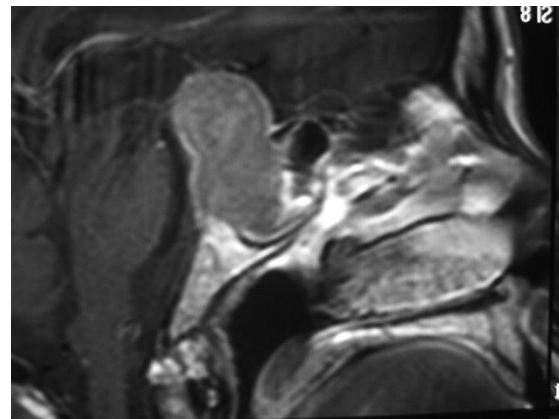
MRI (sagittal view) of a macroadenoma with a suprasellar and left cavernous sinus invasion
